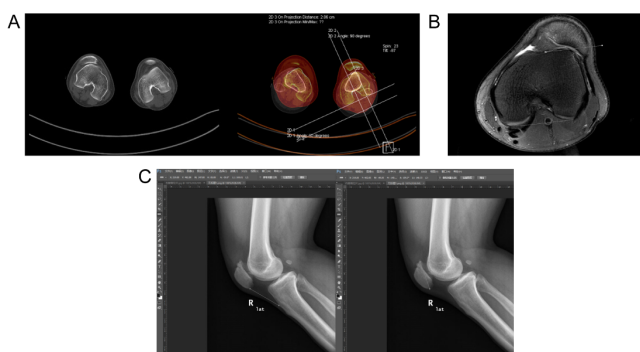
Logistic regression indexes of patient’s injured (right) knee. (A) Preoperative CT test showed the patella subluxation. The TT-TG value of the patella femoral joint was 2.14 cm; (B) Lateral femoral condyle inclination angle was 14.8°; (C) The Insall-Salvati value was 1.26. These parameter values were detected by Photoshop CC 2015 Preoperatively.
